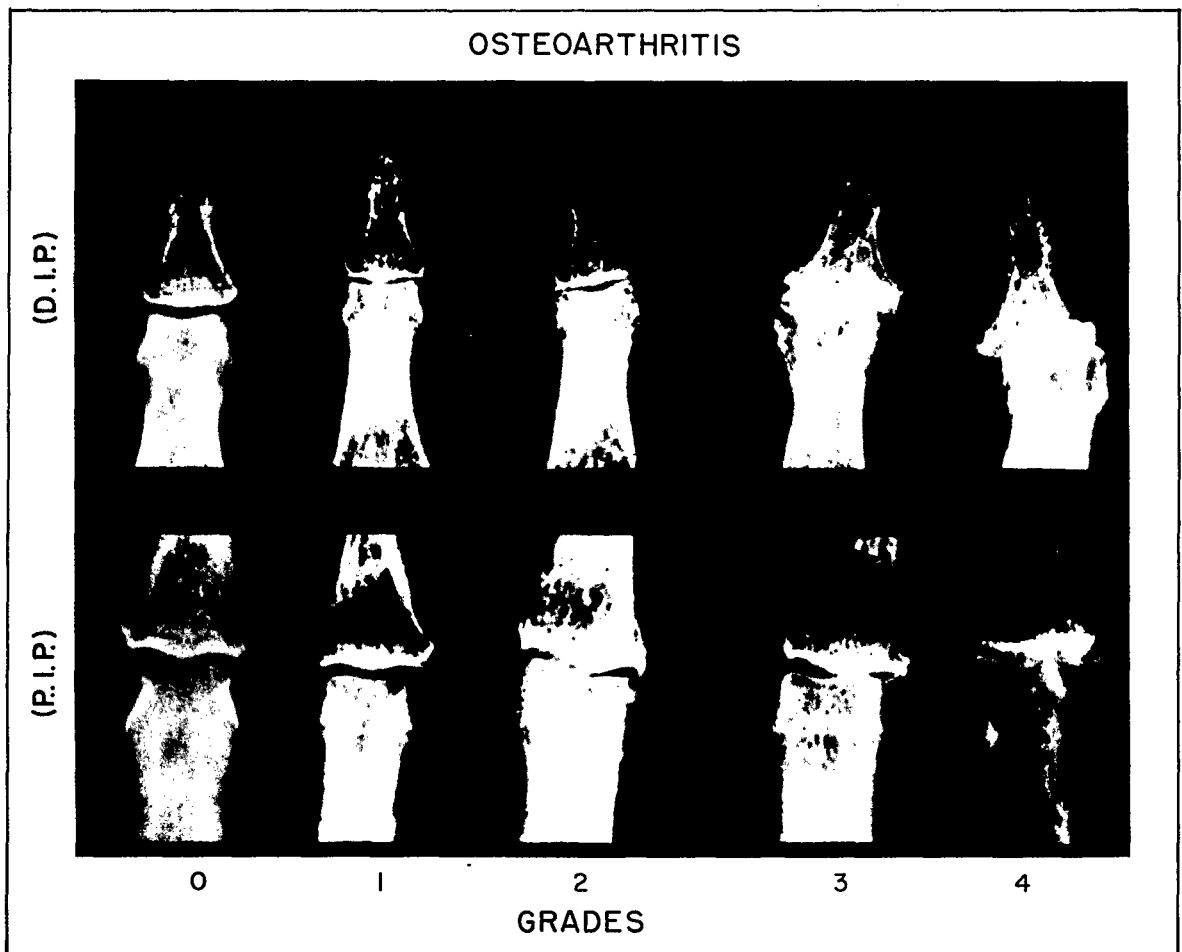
Gratings of osteoarthritis in distal-interphalangeal (D.I.P.) and proximal-interphalangeal (P.I.P.) joints of the hands. Radiograph series from the Clinical Center, National Institutes of Health used in the Health Examination Survey, Cycle I.
